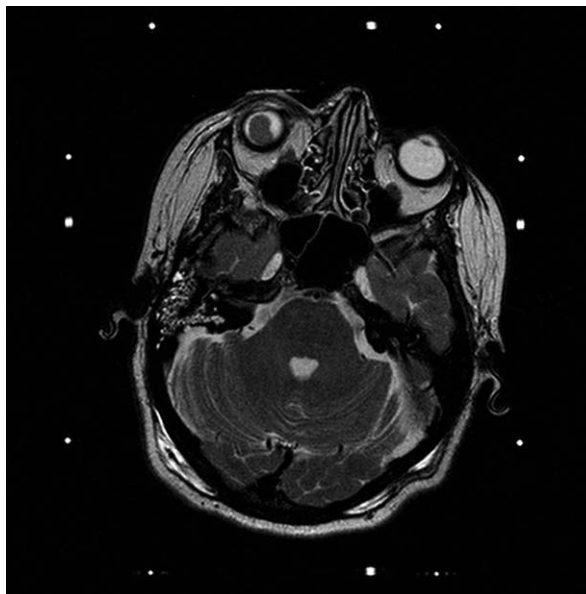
This stereotactic MRI was used in planning for gamma-knife radiosurgery in a 59-year-old woman. The T2-weighted sequence shows a hypointense lesion in the right ocular globe that is suggestive of uveal melanoma.
